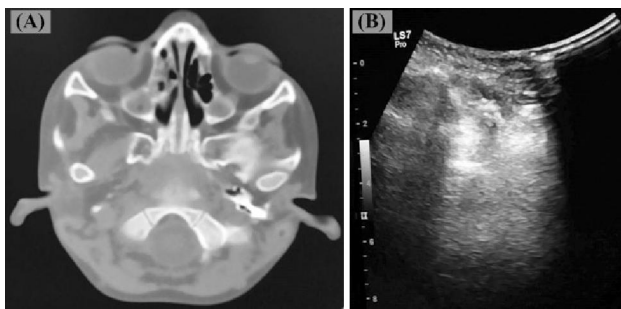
Maxillary sinusitis seen on CT scan and Ultrasound
